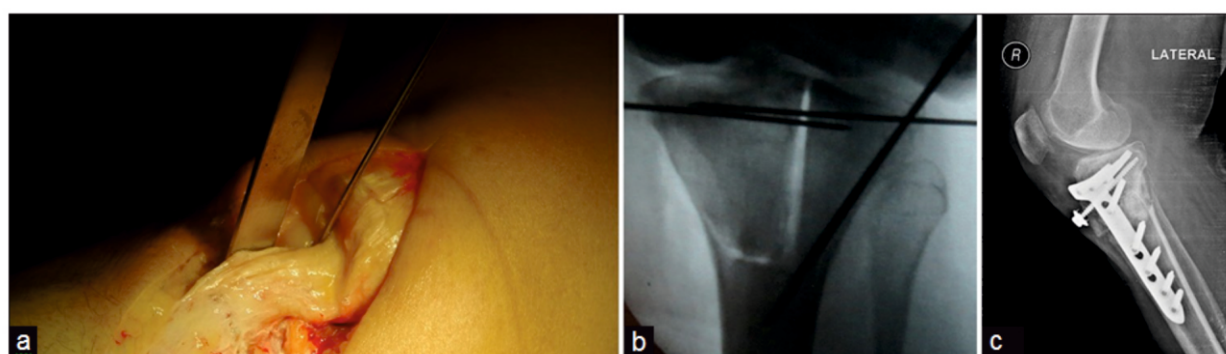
(a) Clinical photograph depicting vertical limb of the osteotomy being made lateral to the patellar ligament; (b) vertical limb of osteotomy passes near lateral tibial spine. Curved osteotomy is directed medially from tibial tuberosity, ending above insertion of superficial medial collateral ligament. Two transverse K-wires protect hinge at joint level and prevent separation of condyles. Two additional K-wires inserted from lateral side to prevent fracture of narrow lateral cortex; (c) Lateral X-ray shows osteotomy fixed with locking plate. It shows a screw with spiked washer to prevent patellar ligament avulsion
